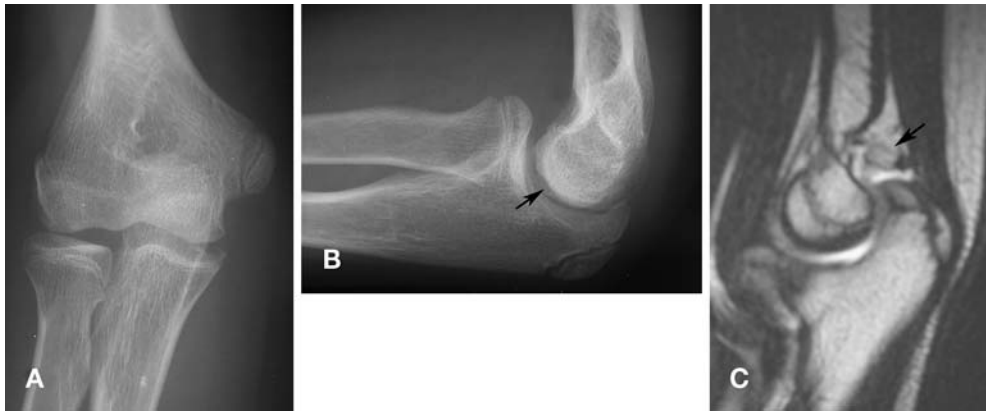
A A 15-year-old male with elbow pain for the past 1 year and surgically confirmed OCD of the capitellum and intra-articular loose body. Anteroposterior radiograph of the elbow shows no abnormality. B A 15-year-old male with elbow pain for the past 1 year and surgically confirmed OCD of the capitellum and intra-articular loose body. Lateral radiograph of the elbow shows subtle
